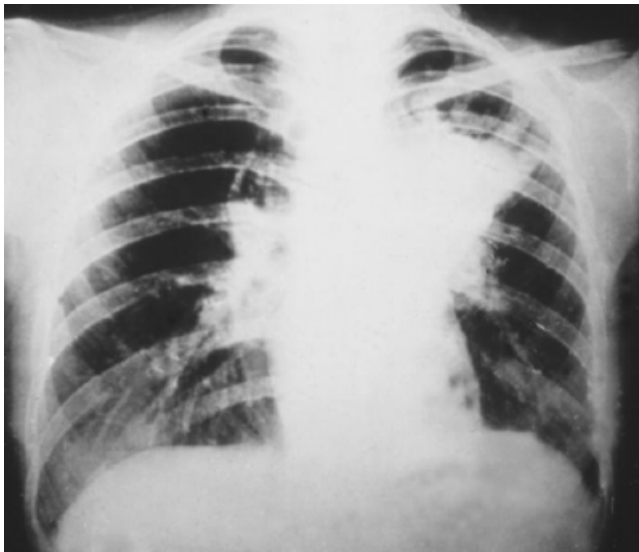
Chest radiograph of a patient with blastomycosis. Courtesy of PHIL, CDC.
